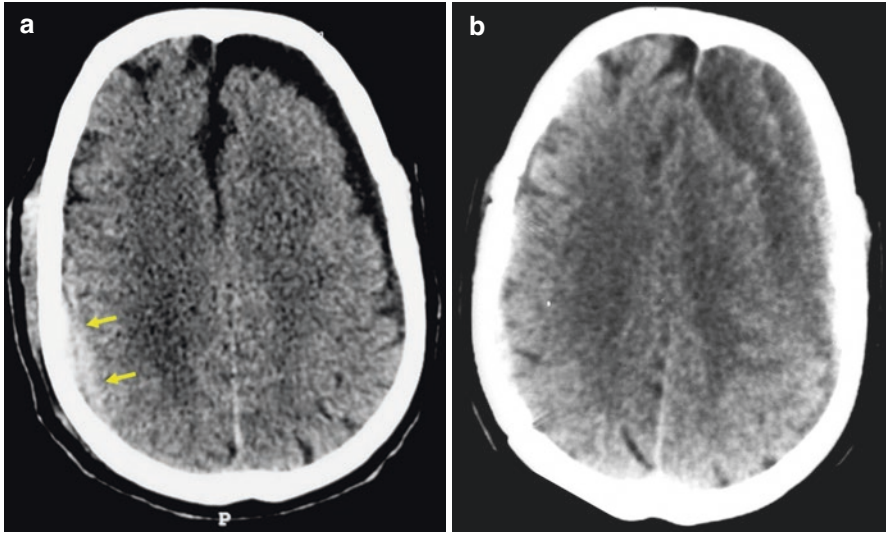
Case 5. Chronic subdural hematoma preceded by traumatic subdural hygroma in a 69-year-old man following a traffic accident. The initial CT-scan on admission showed a mild acute subdural hematoma on the right side (arrows) and a small subdural hygroma on the opposite side (a). Ten weeks later, a heterogeneous chronic subdural hematoma was present on control CT-scan on the left side [on the opposite side of the initial trauma] (b)
